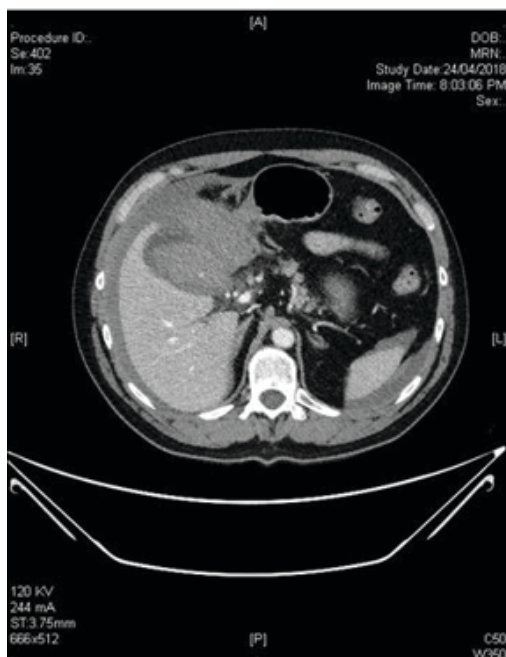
Axial preoperative CT abdomen.
